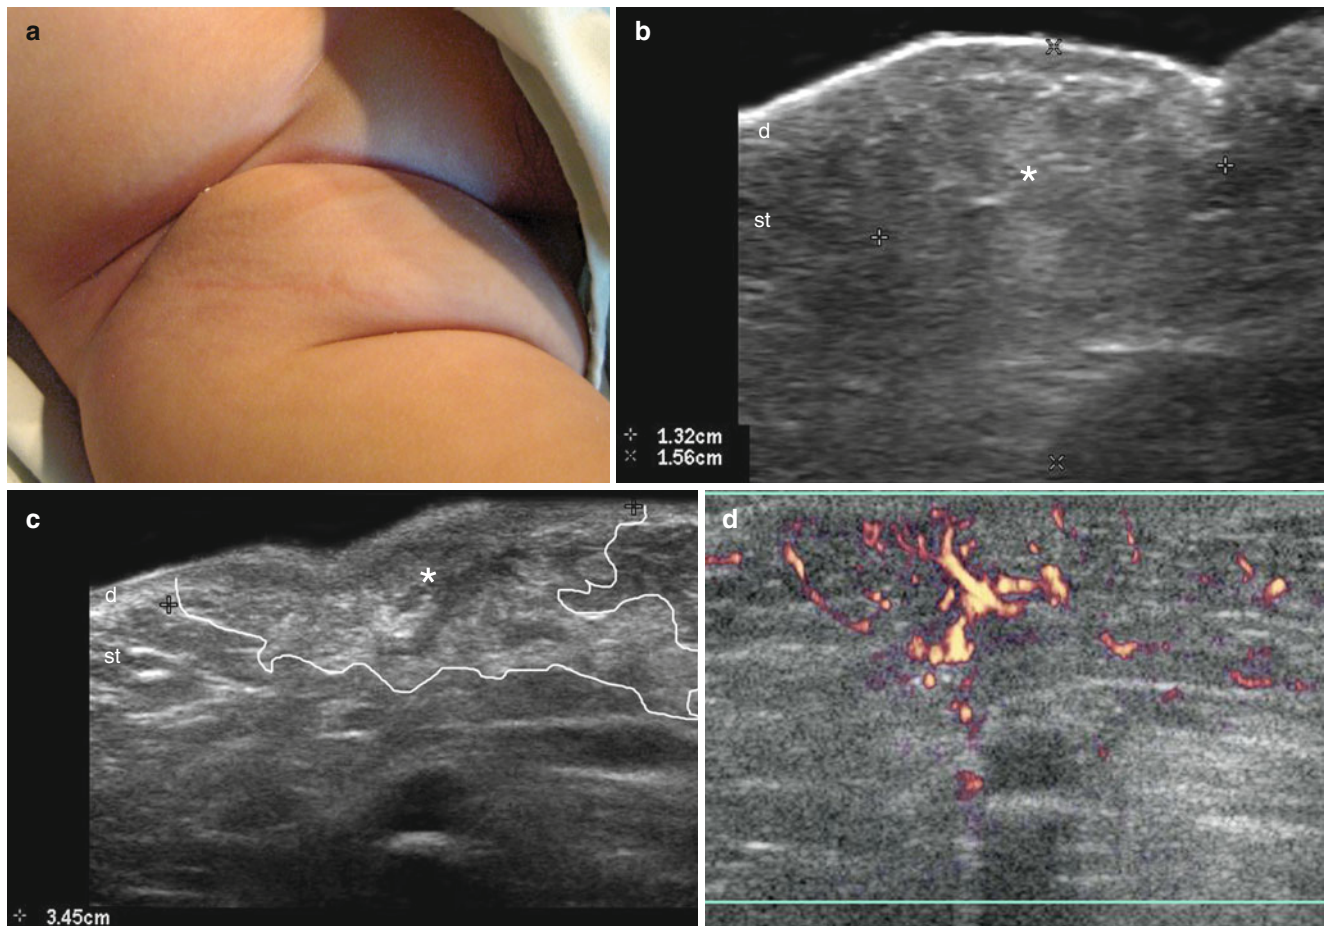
(a–d) Kaposiform hemangioendothelioma. (a) Clinical swelling in the right groin. (b) Grey scale ultrasound (transverse view) shows ill-defined hyperechoic and heterogeneous region (*, measuring 1.32×1.56 cm, between markers; transverse and depth axis respectively) that affects mostly the subcutaneous tissue and to a lesser extent
